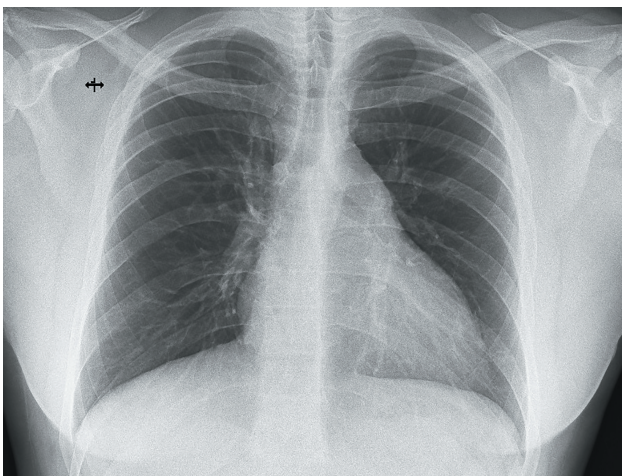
Chest X-ray showing cardiomegaly with clear lung fields.
